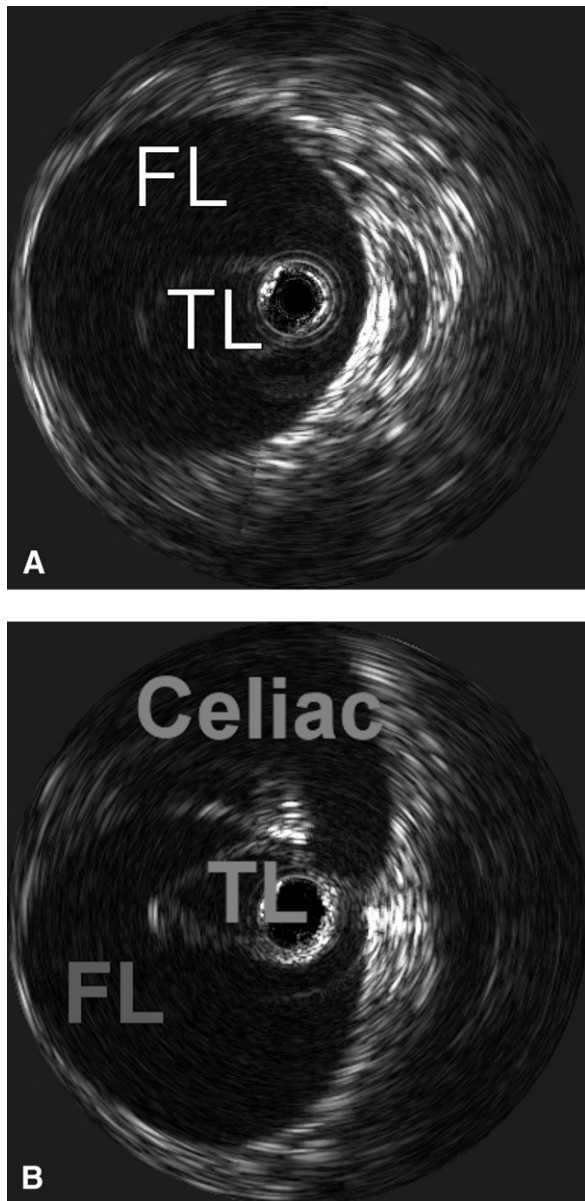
Intravascular ultrasound (IVUS) evaluation of the thoracic aorta. A, The true lumen (TL) is compressed and free floating in the thoracic aorta, and the false lumen (FL) is larger than the TL. IVUS has been used to confirm that the wire is in the true lumen. B, The relationship of the dissection flap/true lumen (TL) to the celiac artery is shown.
